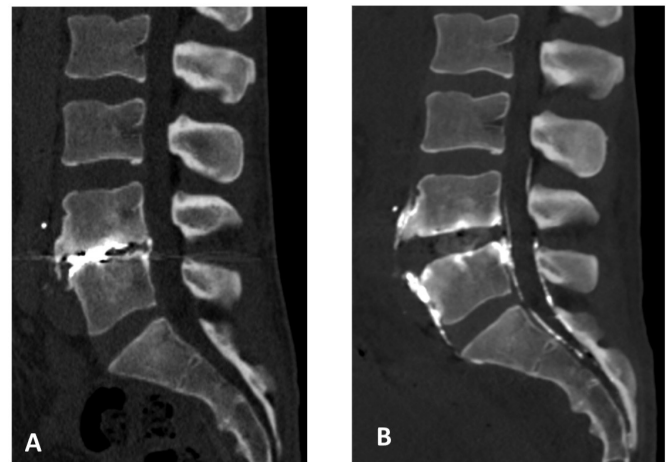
Lumbar CT scan before material disintegration and after surgery. (A) 7 years before lumbar CT scan: sagittal section with well limited hyperdense material corresponding to the bullet. (B) Lumbar CT scan after surgery, sagittal section with removal of hyperdense material and sequelae of disintegration in the epidural space.
